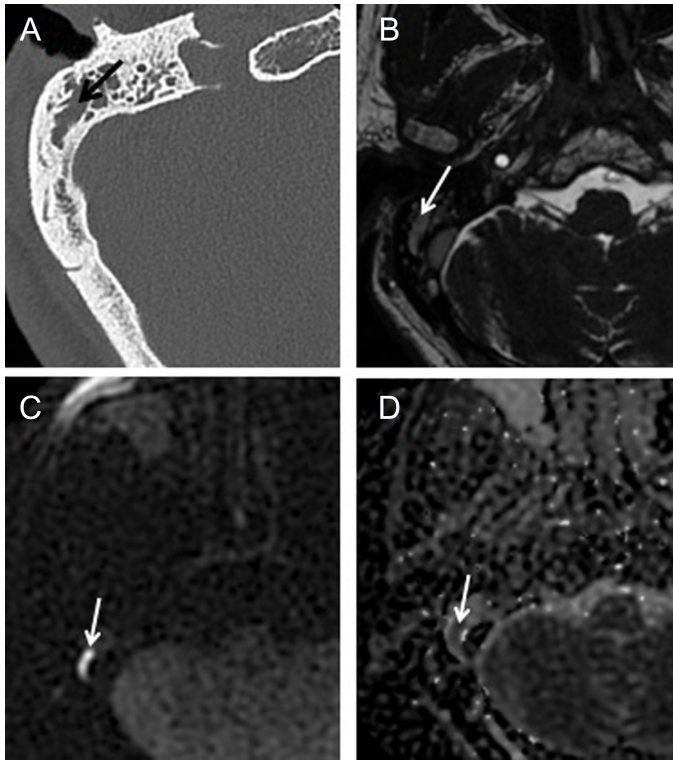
(A) In the axial CT image, opacifications (arrow) within the mastoid air cells on the right; it is difficult to distinguish cholesteatoma from other secretions with only CT. (B) Thin-sliced T2-weighted MR image shows hypointense secretions (arrow). (C, D) Fusiform-shaped diffusion restriction in this area (arrows) compatible with cholesteatoma. CT, computed tomography; MR, magnetic resonance.
